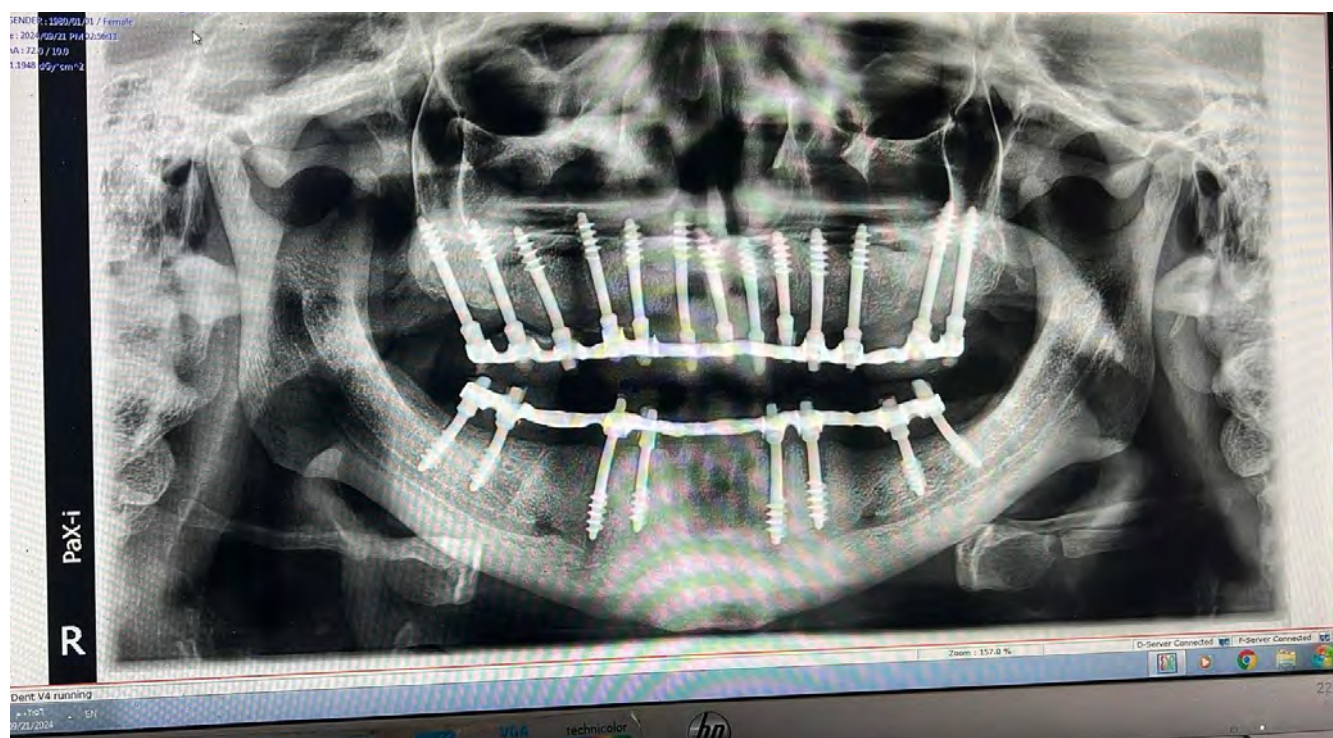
One-year follow-up panoramic radiograph, showing a ring-bridge design of the prosthetic work pieces.
